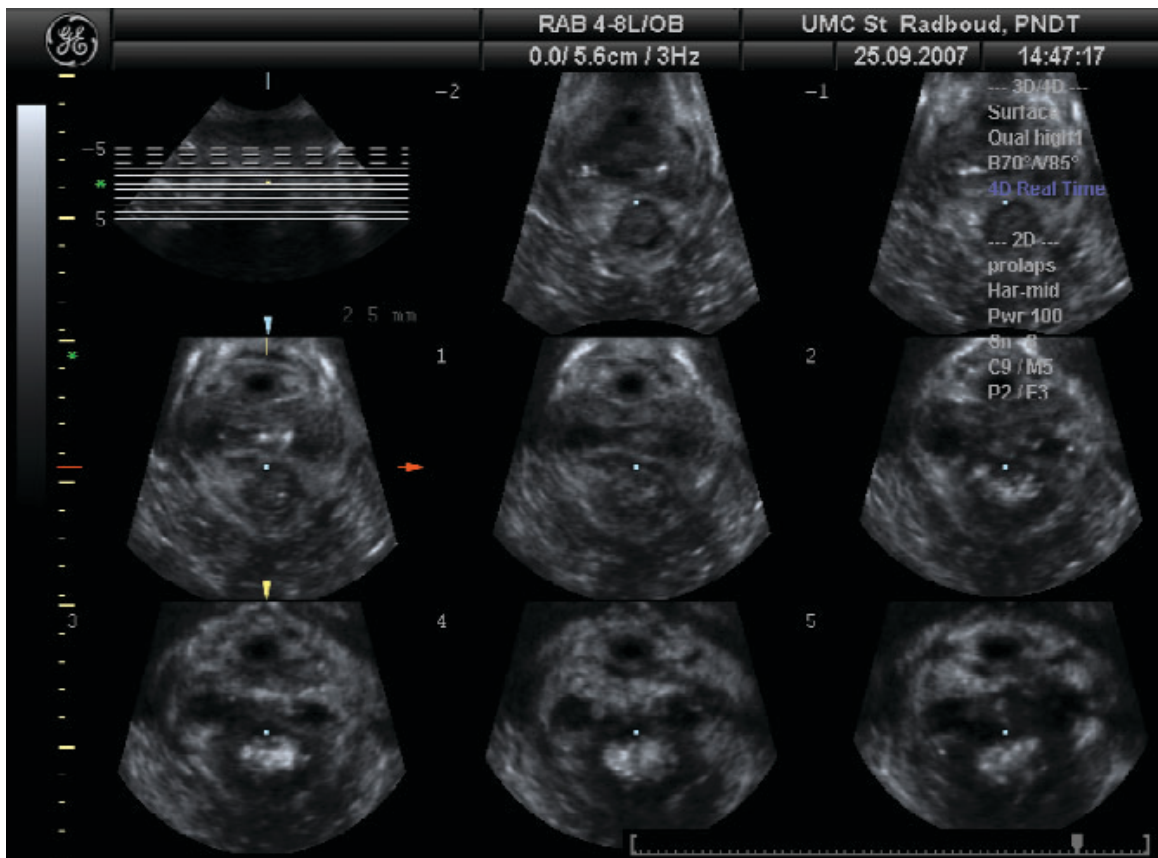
Tomographic ultrasound imaging (TUI) in oblique axial plane. Both-sided avulsion of the levator ani muscle from the symphysis pubis.
